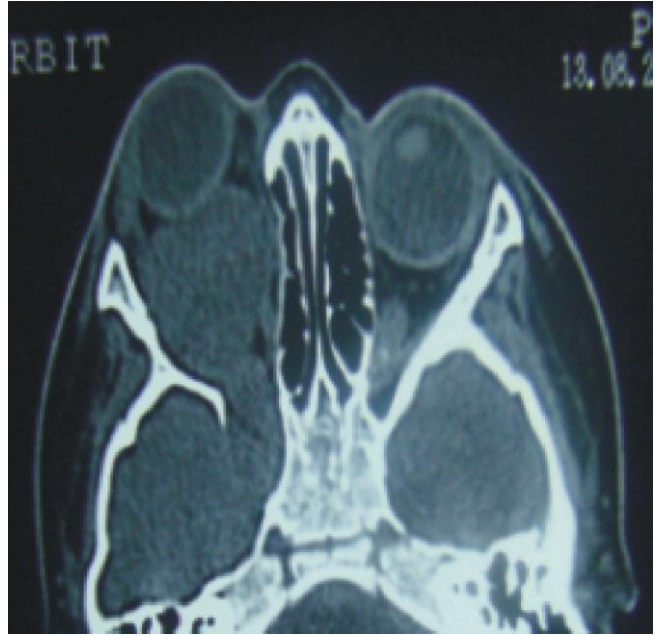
Computed Tomography (CT) scan revealing the lesion involving both intra and extra-conal territories of right orbit pushing the globe superiorly and laterally and infiltrating extra-durally along the right middle cranial fossa.
